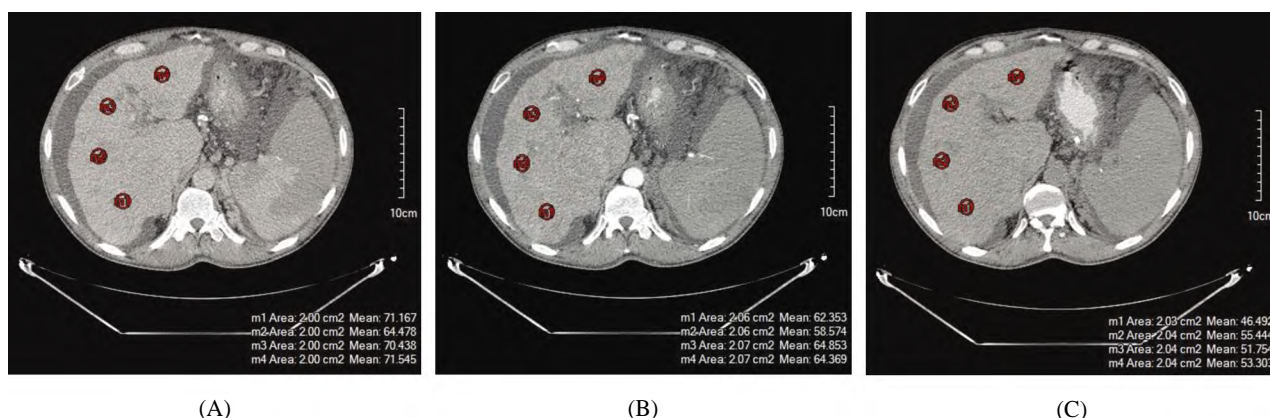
Triphasic CT of the liver in a 51 years old male patient with liver cirrhosis (Child-Pugh grade C), displayed irregular nodular hepatic contour, enlarged caudate lobe, attenuated hepatic veins, portal venous thrombosis and ascites. (A) Precontrast. (B) Arterial phase. (C) Porto-venous phase. There is increase in ROI measurement in the arterial and portal phases compared to the pre-contrast phase. The ROI measurement in the portal phase was lower than the arterial phase indicating slow drainage of the contrast media from the liver parenchyma due to portal out- flow obstruction which has an impact on liver function by decreasing portal perfusion. The calculated CEF was increased= 1. 1.
